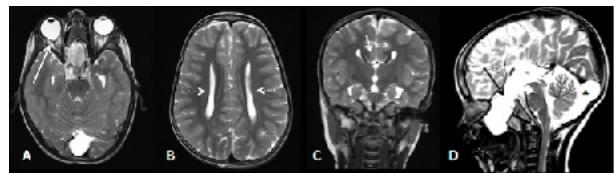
MRI of the same patient depicting agenesis of the corpus callosum, sphenoethmoidal encephalocele, and right-sided ocular anomalies. (A) Axial T2-weighted image demonstrating a coloboma of the right eye with a tortuous optic nerve (white arrow). (B, C) Axial and coronal T2-weighted images showing parallel orientation of the lateral ventricles ("racing car" sign, dotted arrow) and "Viking helmet" appearance (white arrow), characteristic of corpus callosal agenesis. (D) Sagittal T2-weighted image depicting a bony defect involving the sphenoid and ethmoid bones with herniation of brain parenchyma forming an encephalocele (black arrow). An incidental posterior fossa arachnoid cyst is also noted (asterisk).
